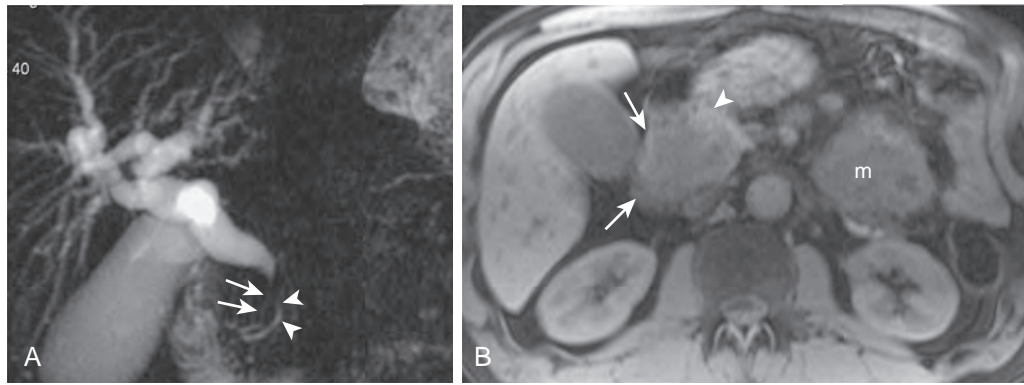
Distal duct cholangiocarcinoma. A. Coronal thick-slab MRCP shows a high-grade stricture of the intrapancreatic bile duct (arrows) resulting in proximal biliary ductal dilation. The pancreatic duct (arrowheads) is normal in caliber. B. T1-weighted, fat-suppressed, unenhanced abdominal MRI shows a mass (arrows) involving the pancreatic head that is low in signal intensity relative to the adjacent normal pancreatic parenchyma (arrowhead). Pathologic analysis revealed cholangiocarcinoma. A large, mesenteric metastasis (m) was present at the time of diagnosis.
